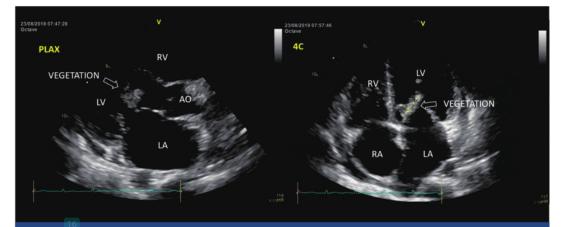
The transthoracic echocardiography view of parasternal long axis and 4-chamber view shows the presence of left atrial dilatation and vegetation in anterior mitral valve leaflets.
